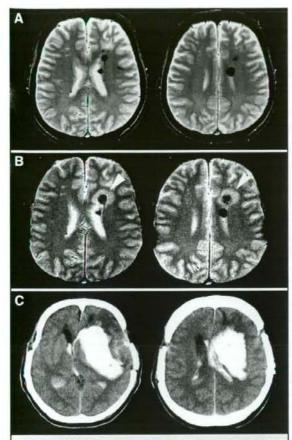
Magnetic resonance imaging (MRI) scans demonstrating sequential changes in MBs transforming into symptomatic hemorrhages. A, in a 49-year-old man with ischemic moyamoya disease (MMD), multiple MBs were revealed in the initial 3-T MRI study. Superficial temporal artery-to-middle cerebral artery (STA-MCA) anastomosis with encephalomyosynangiosis was performed on both hemispheres. One month after completion of the surgery, the number and size of the MBs increased with perifocal edema (B, arrowhead). C, 4 months after surgery (5 mo after the initial MRI study), fatal intracerebral hemorrhage (ICH) occurred with intraventricular perforation around the region in which enlarged MBs were demonstrated.
